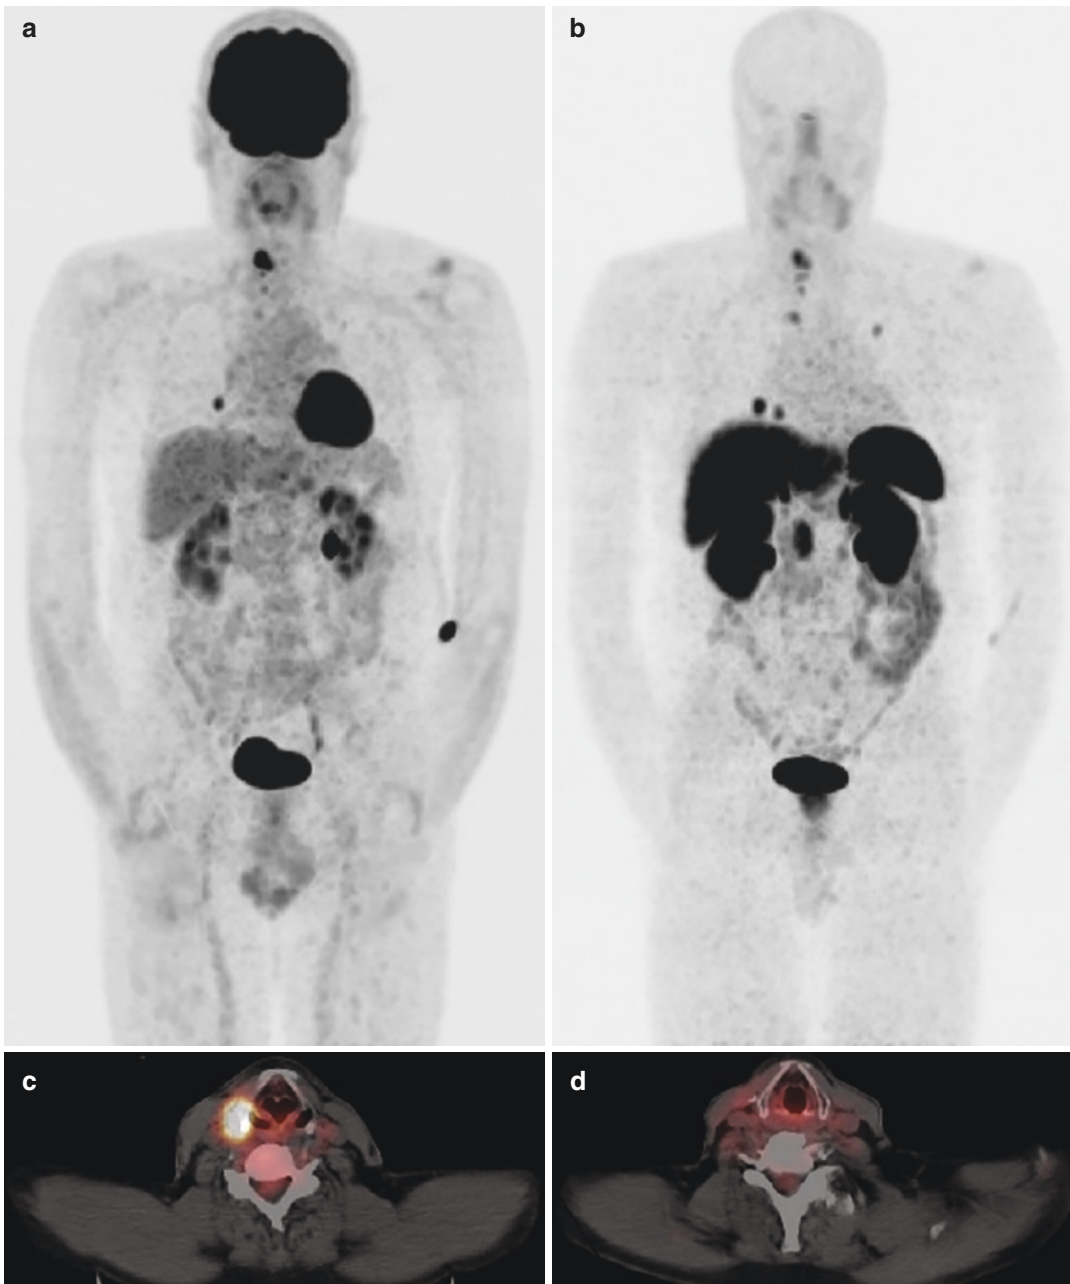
60-year-old male patient after thyroidectomy, several subsequent operations, several radioiodine treatments (including one therapy after retinoic acid pretreatment) because of follicular Hürthle cell carcinoma (pT3m cN1) without significant radioiodine uptake. (a) FDG-PET/CT (MIP) showing local recurrence and lung metastases. (b) Ga-68-DOTATATE-PET/CT (MIP) showing
